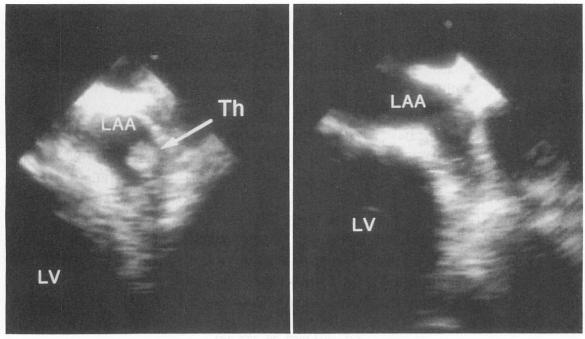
Transesophageal echocardiograms of a patient (case 1) with thrombi in the left atrial appendage
